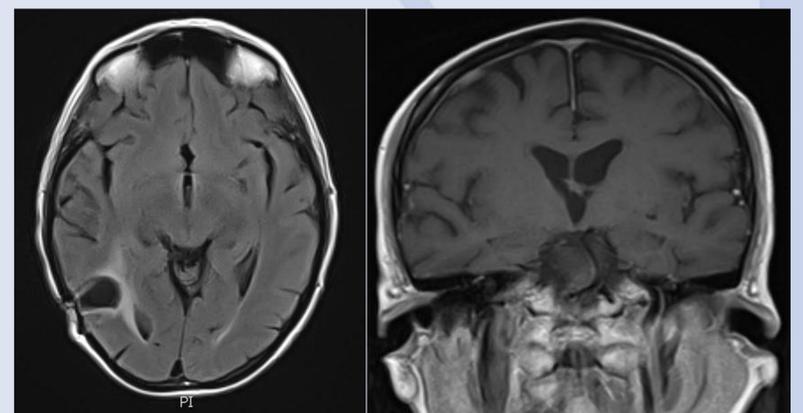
Improved MRI appearances in August 2017 following prolonged IV imipenem therapy
